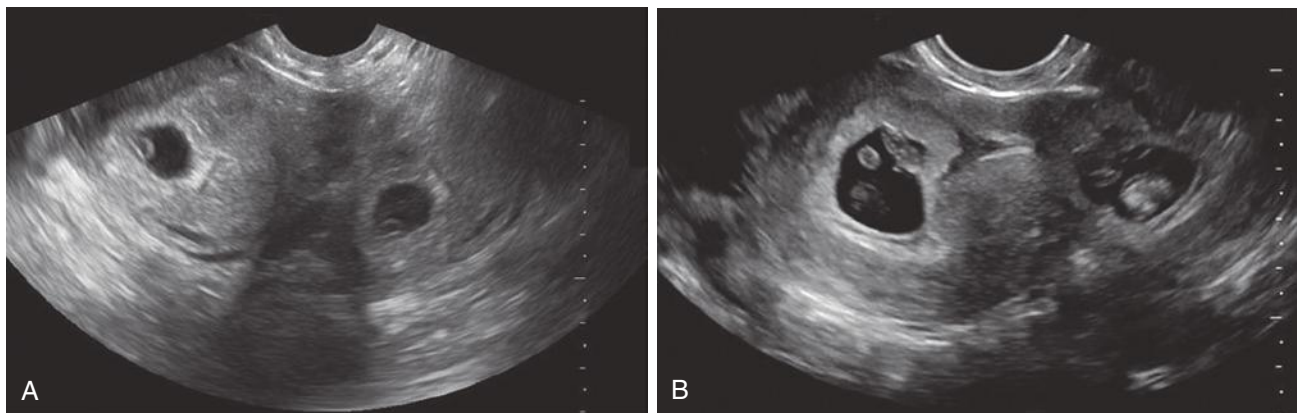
A, Longitudinal transvaginal sonography demonstrating an intrauterine pregnancy on the left and the mirror image artifact of the image on the right. B, Longitudinal transvaginal ultrasound image demonstrating an intrauterine pregnancy on the left and mirror image artifact on the right. (From Malhotra R, Bramante RM, Radomski M, Nelson M: Mirror image artifact mimicking heterotopic pregnancy on transvaginal ultrasound: case series. *West J Emerg Med* 15(6):712-714, 2014, used with permission.)
